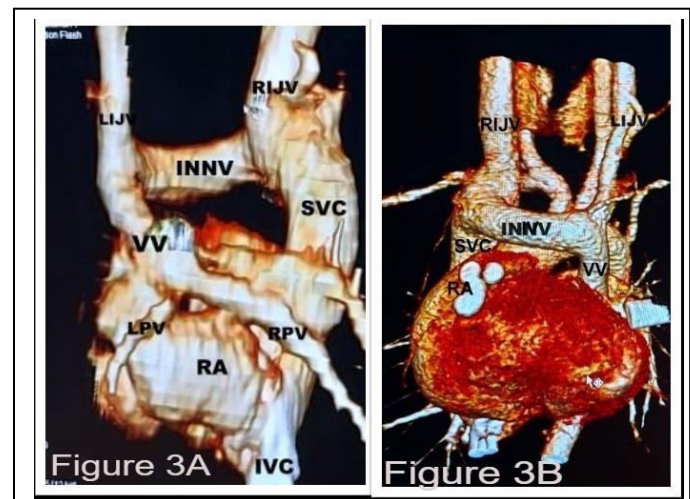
Volume-rendered technique of computed tomography (posterior projection, Figure 3A) demonstrating Left and Right Pulmonary Veins (LPV, RPV) draining into Vertical Vein (VV), Innominate Vein (INN), Superior Vena Cava (SVC), and Right Atrium (RA).
